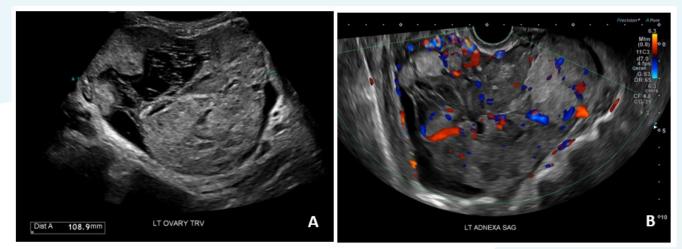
Ultrasound of left adnexa. A. Transverse gray scale left adnexal multilocular solid mass. B. Sagittal colour Doppler US demonstrates moderate vascularity, colour score 3.
